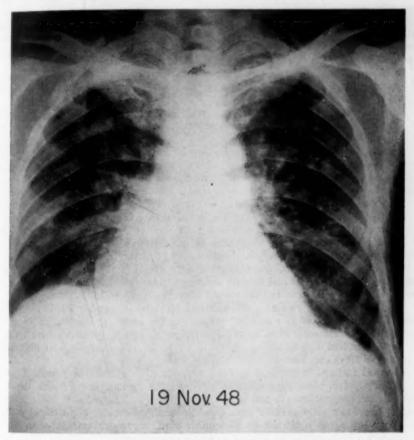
Case 5. Roentgenogram of the chest taken six months after the previous film. This reveals a diffuse infiltration of all lobes, both lungs. The cardiac outline shows evidence of right ventricular dilatation.
